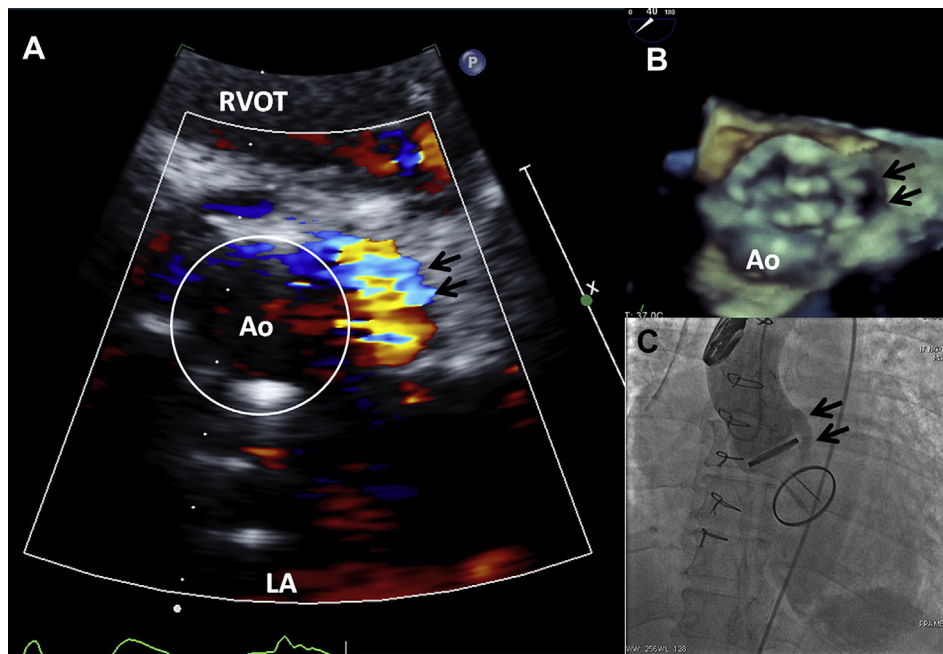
Angiographic projection guided by prior echocardiographic assessment. The aortic paravalvular leak is shown with double arrows in 3 o' clock position of the aortic annulus (circular ring) on this parasternal short axis view (A) and confirmed with a volume rendered transesophageal three dimensional echocardiographic aortic enface view (B). Since the defect is on the left side of the prosthesis, ascending aortogram in anteroposterior projection (C) is the single best projection for profiling this defect. RVOT—right ventricular outflow tract; LA – left atrium.
